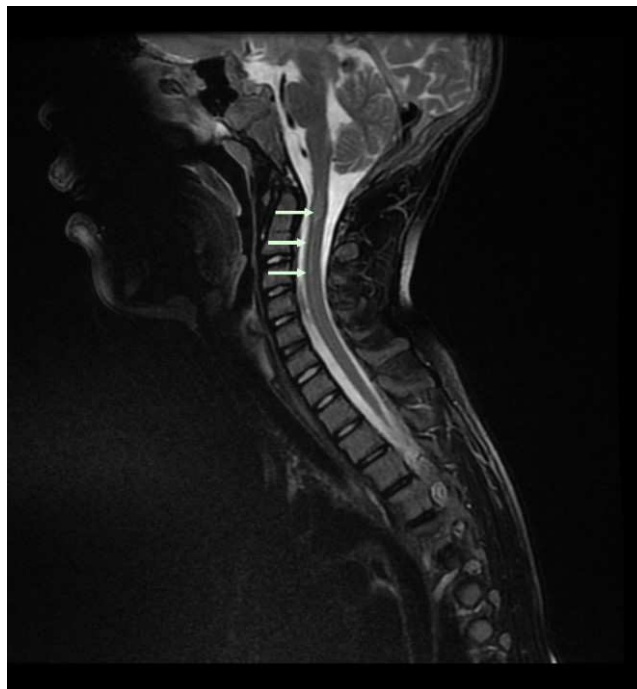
Sagittal T2-weighted [A] magnetic resonance images of the spinal cord, showing a long rounded lesion (green arrows) within the cervical cord: this intraspinal ependymoma occurred in an NF2 child who had upper limb paraesthesia and motor deficits.
